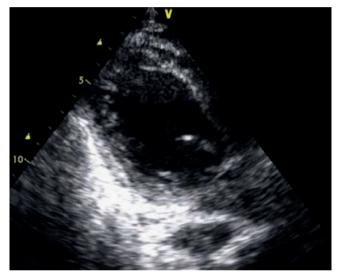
Echocardiography, apical oblique view. In the area of LV apex and median segments of the inferior wall, there are additional trabeculae.
